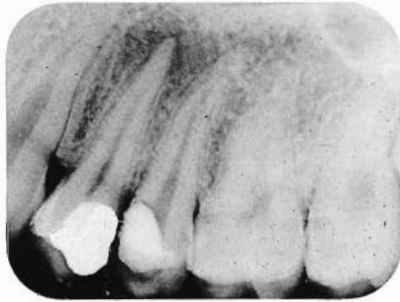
Pre-treatment radiograph of the maxillary right premolar (1975). Observe the apical lesion on the first premolar
